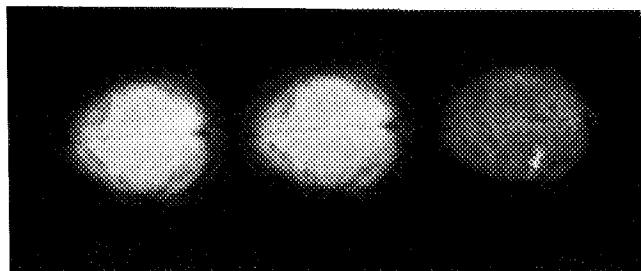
MRI: activation of the motor cortex. Selected two input images out of 122 (acquired at time 57 and 64 s, respectively), originally,  $64 \times 64$  pixels each, EPI on 1.5 T GE Signa scanner,  $TR=1000$  ms and  $TE=40$  ms. The third image is the second PC image.
